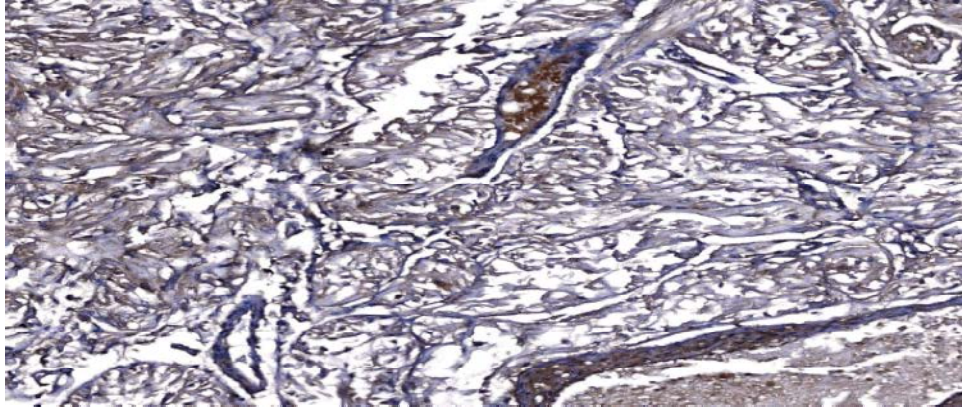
Pilocytic astrocytoma showing PSMA positive expression of endothelial lining of the blood vessels. Original magnification power 200x.
